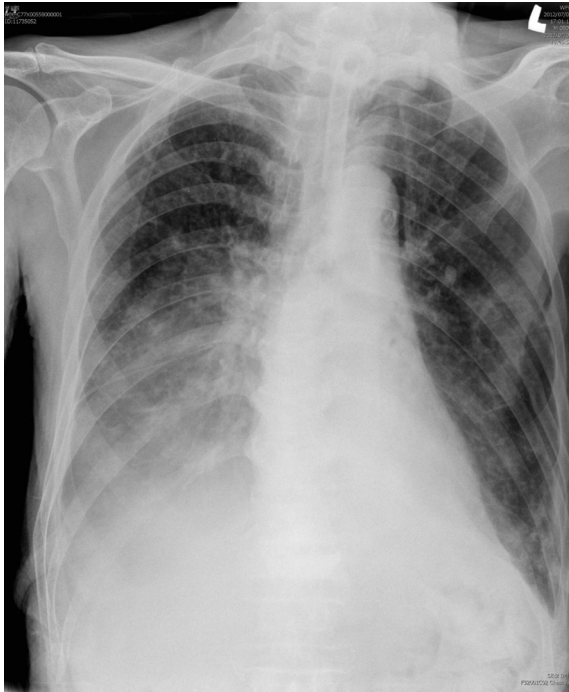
Chest radiograph revealing the infiltration patch of the right lower lobe of the lung.
